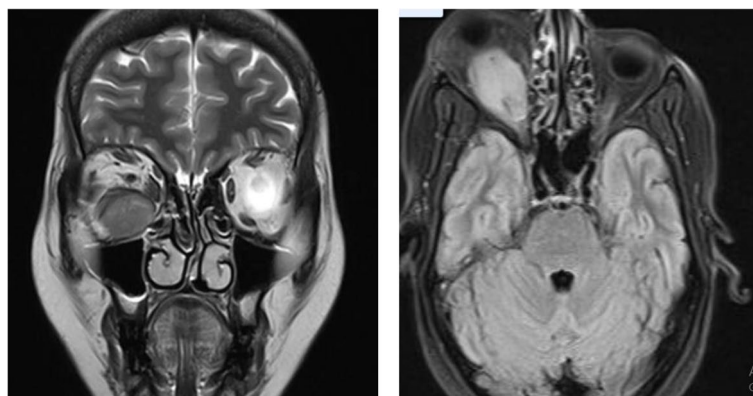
Contrast-enhanced MRI showing mass arising from the inferior rectus muscle just abutting the optic nerve
